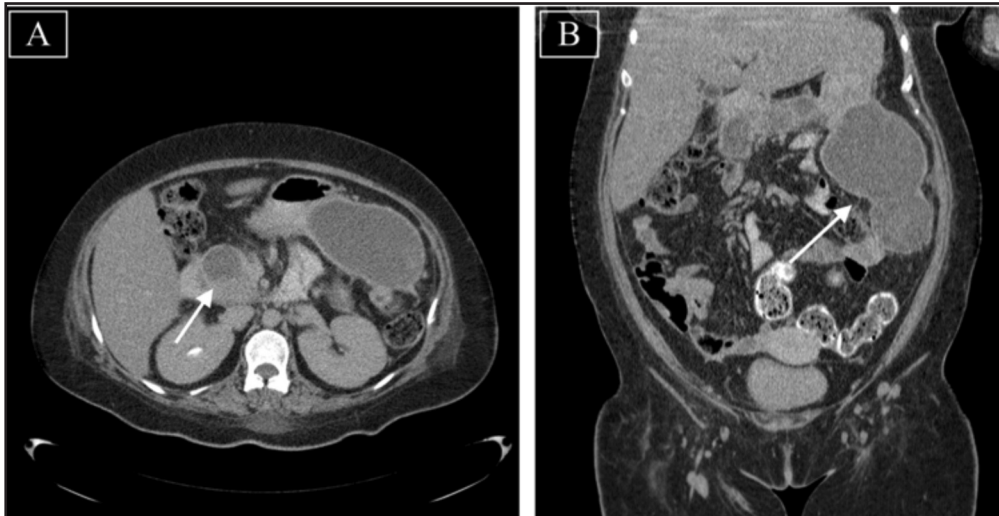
and 1B: Axial and coronal CT showed well-defined and encapsulated homogenous collection at the head of pancreas extending into the left intraabdominal cavity and compressing the stomach anteriorly.
